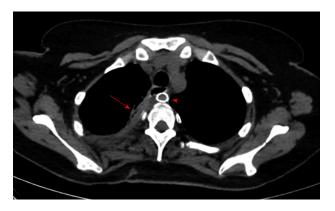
Computed tomography scan with oral contrast done after removal of the T-Tube with both the remnant tract of the T-tube (arrow) and the subclavian artery stent (arrowhead) seen.
